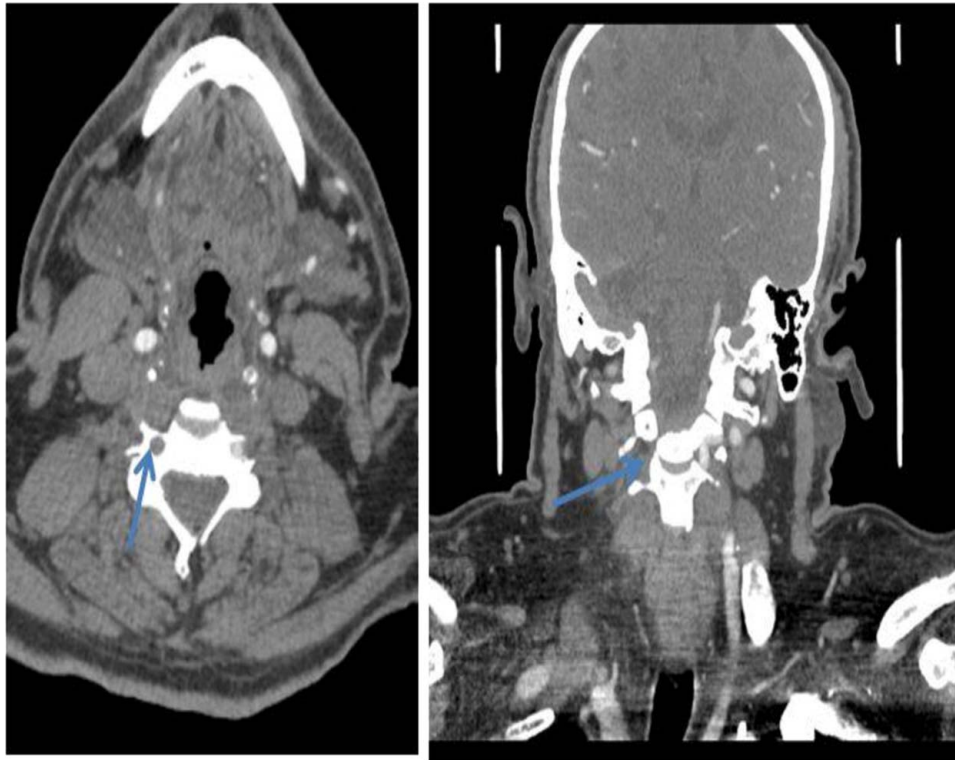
Axial and coronal views of neck computed tomography angiography show complete occlusion in right vertebral artery.
